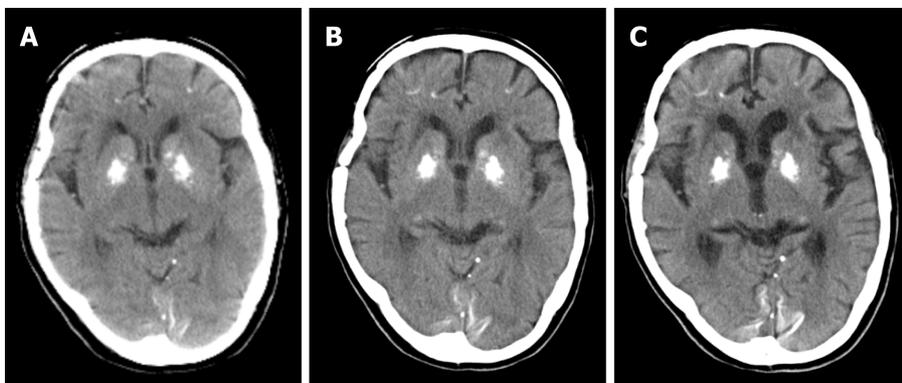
Computed tomography images of the proband. A: 65 yr; B: 69 yr; C: 75 yr.
